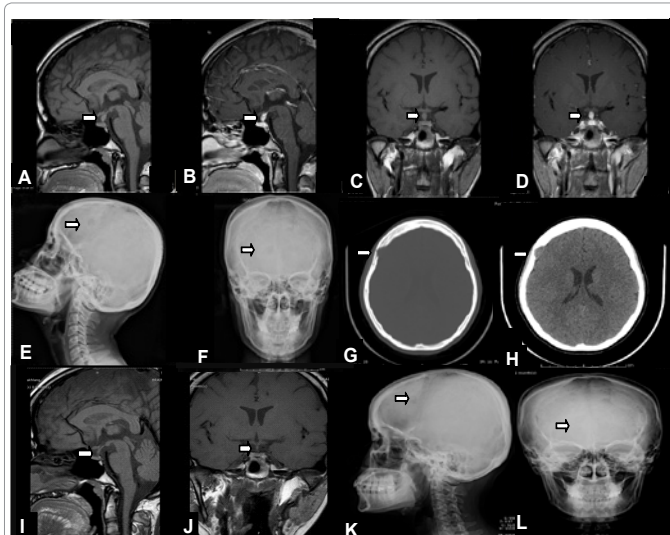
Pituitary stalk thickening and osteolytic lesion at patient's skull at diagnosis and 2 years later. Magnetic resonance imaging of the pituitary demonstrated an enlarged pituitary stalk (4.4 mm) (arrow) without a demonstrated posterior bright spot. A and B) T1W sagittal view without and with Gadolinium, respectively; C and D) T1W coronal view without and with Gadolinium, respectively. E and F) Plain skull film demonstrated osteolytic lesion (arrow). G and H) A computerized tomography brain bone window view demonstrated an extra-axial soft tissue forming associated with osteolytic bony destruction. I and J) T1W sagittal and coronal view without Gadolinium of the patients, 2 year after the diagnosis. K and L) Follow-up plain skull at 2 years later demonstrated improved osteolytic lesion (arrow).
